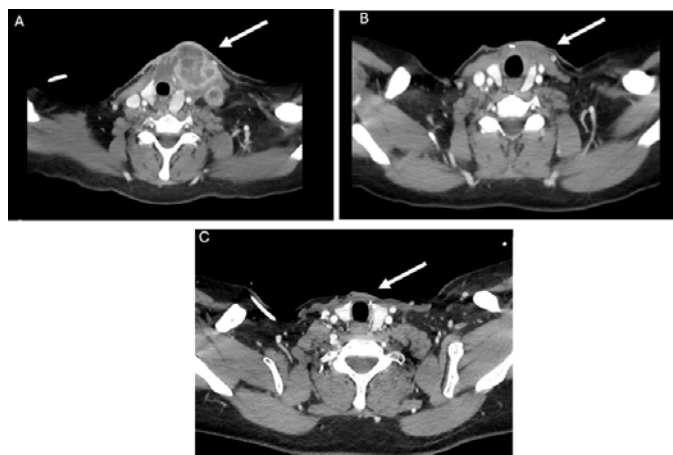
(A) Axial CT image of the neck demonstrating a large centrally necrotic cervical nodal mass in the left neck causing moderate tracheal narrowing, consistent with locoregional recurrence. (B) Axial CT image of the neck at two months following initiation of therapy with tipifarnib demonstrating near complete resolution of the cervical nodal mass. (C) Axial CT image at 12 months following initiation of therapy with tipifarnib demonstrating complete radiographic response with no evidence of residual disease.
